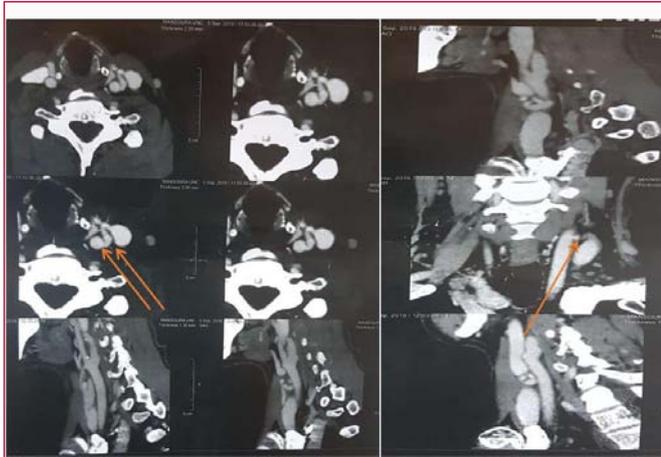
CT angiography of the carotid system: Evidence of arterio-venous fistula between left common carotid artery and left internal jugular vein (Arrow) 2 cm proximal to carotid bulb. The fistulous tract is tortuous (s shaped) (Double arrows). Its caliber is about 4 mm and it is (18 mm) length. No evidence of associated hematoma, leak, thrombus, aneurysmal dilatation or dissection.
